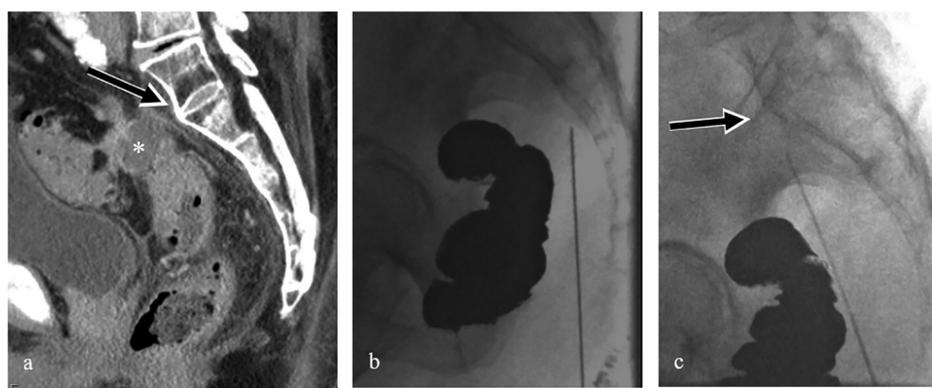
A 77-year-old man with no history of previous abdominal surgery presenting with a presacral abscess caused by acute complicated diverticulitis: a: CT image in the sagittal plane shows small presacral abscess (white asterisk). The abscess is located anterior to S1–S2 (arrow) which can be used as an anatomical landmark on fluoroscopy; b: fluoroscopy image shows the puncture route with the needle pointing cranially in the presacral space. Intrarectal contrast material was used to avoid puncture of the rectum given the close relationship between abscess and rectosigmoid; c: fluoroscopy image shows the needle, which is angulated anteriorly towards the level of S1–S2 (arrow), unfortunately the abscess could not be reached, resulting in technical failure.
